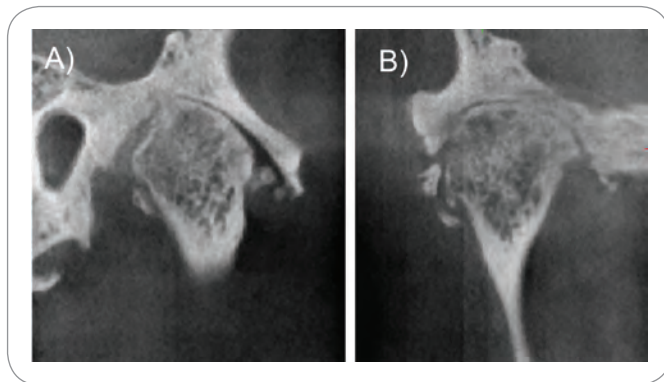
Osseous ankylosis on lateral (A) and coronal (B) CBCT sections showing irregular articular surface, narrow joint space, and continuity of the condylar head with the glenoid fossa at the middle aspect of the condyle. Additionally, small bony fragments, probably representing detached osteophytes, are seen within the joint space.
